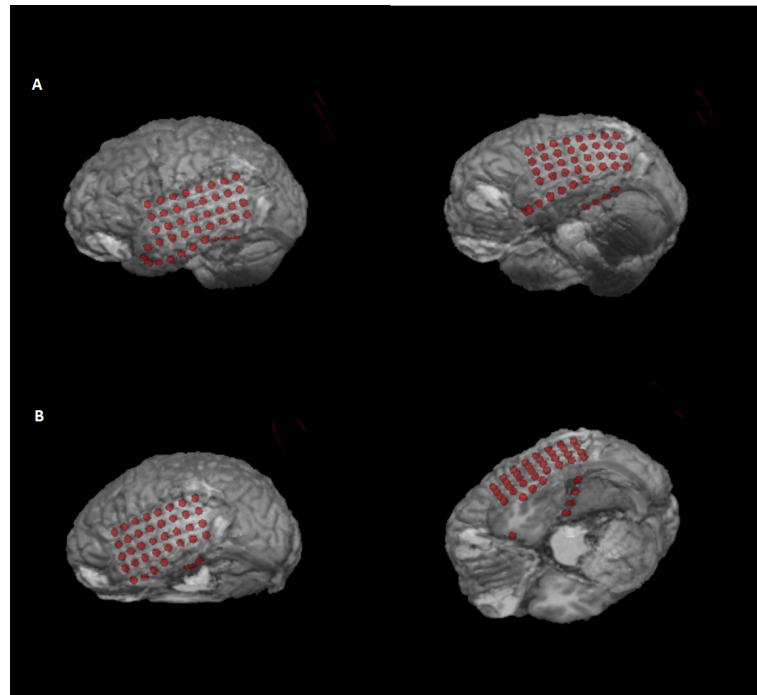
A - 3D visualization, using MRICron, of skull-stripped T1-MRI, from the patient 1, with the electrodes mask. B - 3D visualization of skull-stripped T1-MRI without cerebellum, from the patient 1, with the electrodes mask.
